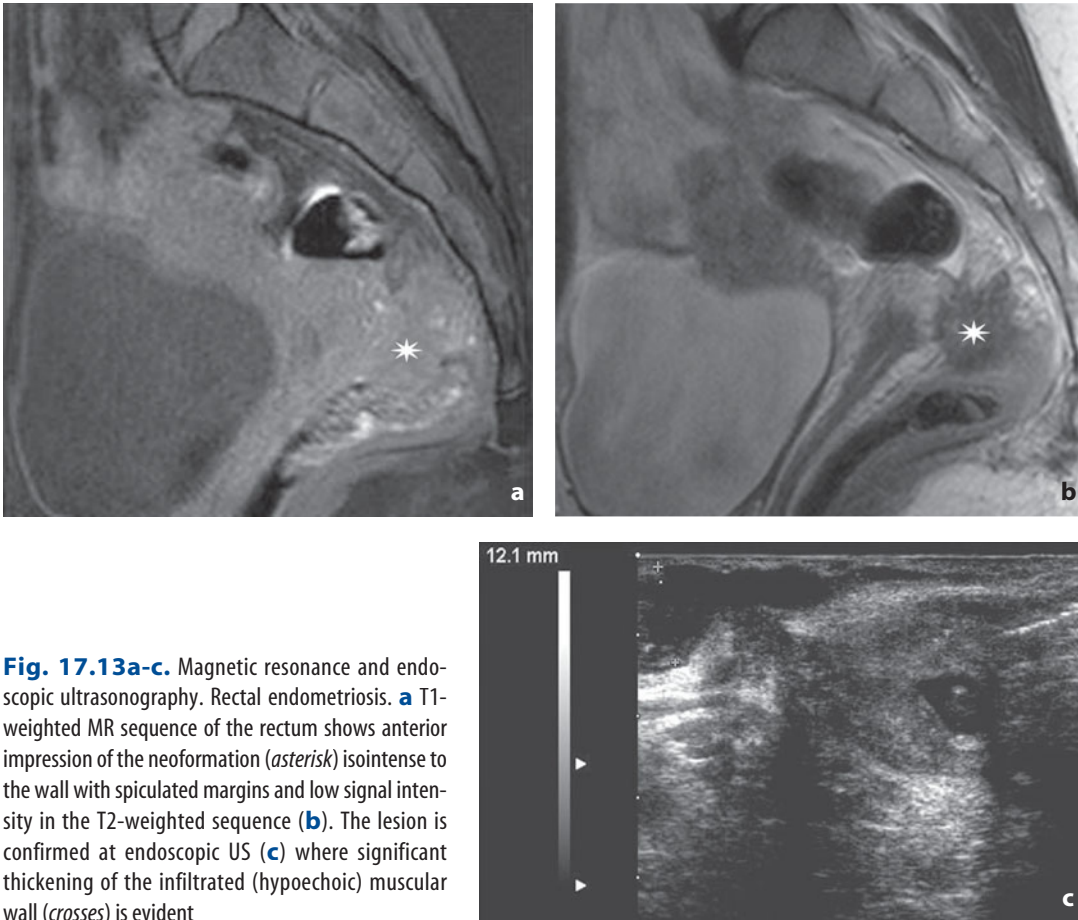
Magnetic resonance and endoscopic ultrasonography. Rectal endometriosis. a T1-weighted MR sequence of the rectum shows anterior impression of the neof ormation (*asterisk*) isointense to the wall with spiculated margins and low signal intensity in the T2-weighted sequence (b). The lesion is confirmed at endoscopic US (c) where significant thickening of the infiltrated (hypochoic) muscular wall (*crosses*) is evident
